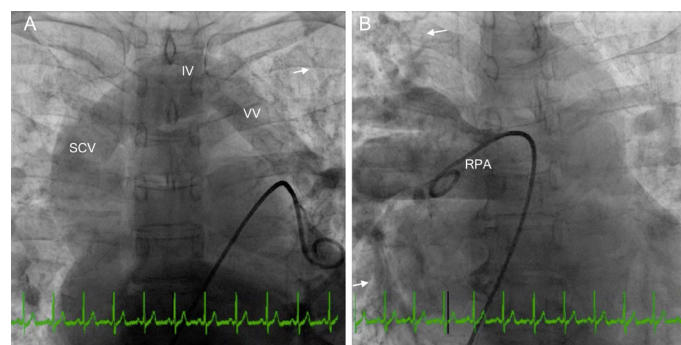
Chest X-ray (A) Configuration of the heart and the superior mediastinal borders resembling a “snowman”; (B) Echo gradient acquisition shows the pulmonary veins (PV) drain into an enlarged vertical vein (VV) which in turn drains into the innominate (IV) vein and then to the superior vena cava (arrow); Right pulmonary artery (RPA)
